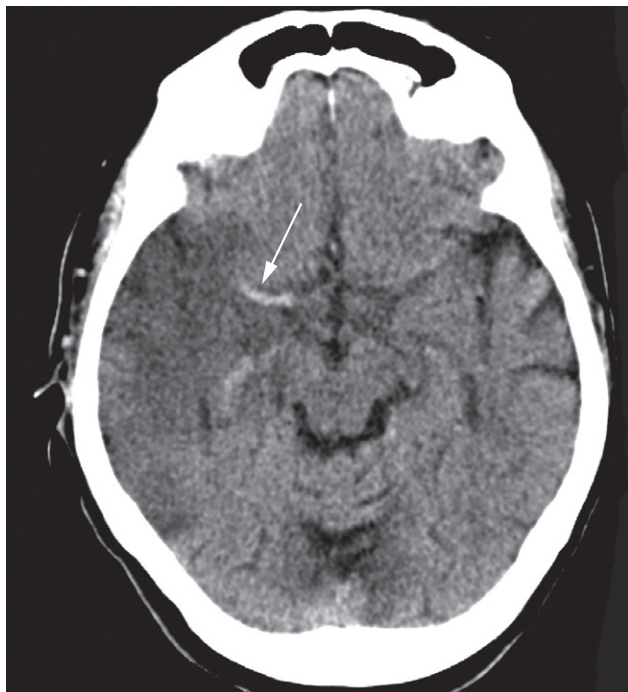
Dense artery sign. Unenhanced CT showing acute thrombus in the right middle cerebral artery (arrow).
